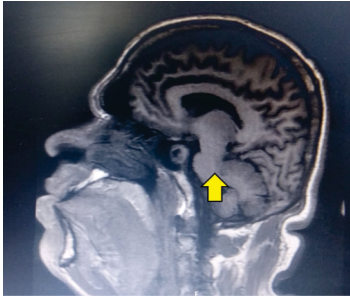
MRI brain was suggestive of pituitary macroadenoma with cystic degeneration focus in anterior pituitary
